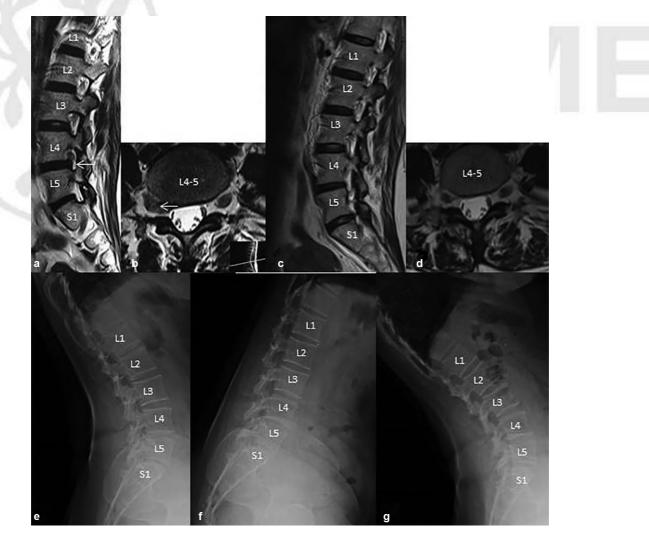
Preoperative (A-sagittal, B-axial) and postoperative (C-sagittal, D-axial) T2-weighted magnetic resonance imaging (MRI) of L4–L5 rightside far-lateral lumbar disk herniation (FLDH), and postoperative lateral radiographs (E-neutral, F-hyperflexion, G-hyperextension).
